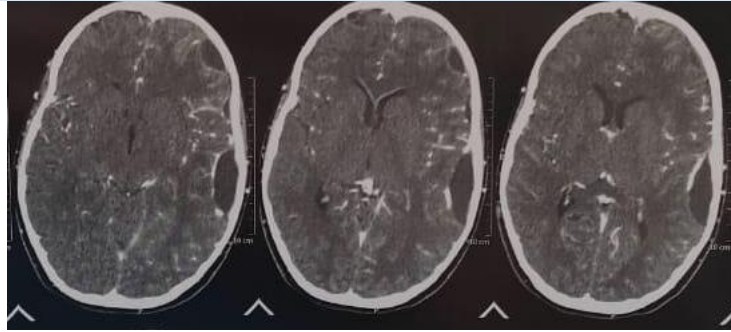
Preoperative CT brain with contrast, axial views show Lt temporal encysted extra-axial collection of hypodense fluid with enhanced wall.
